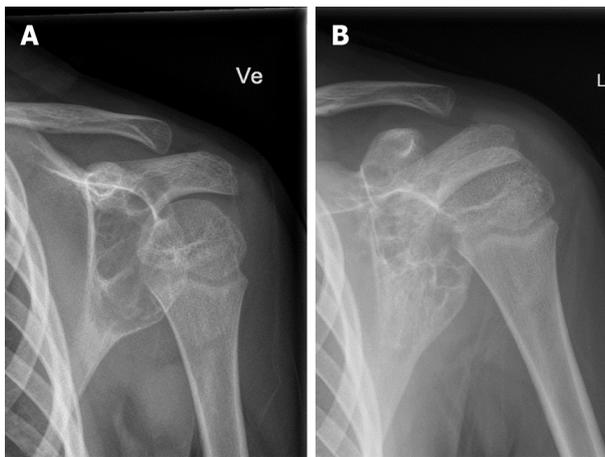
Radiographs of an aneurysmal bone cyst in the proximal femur showing complete ossification. A: At presentation; B: At 26 mo follow-up after sclerotherapy.
